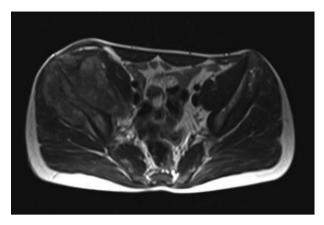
Axial MRI of the pelvis showing a Ewing sarcoma of the right ilium with a large soft tissue component involving iliacus and gluteus minimus
